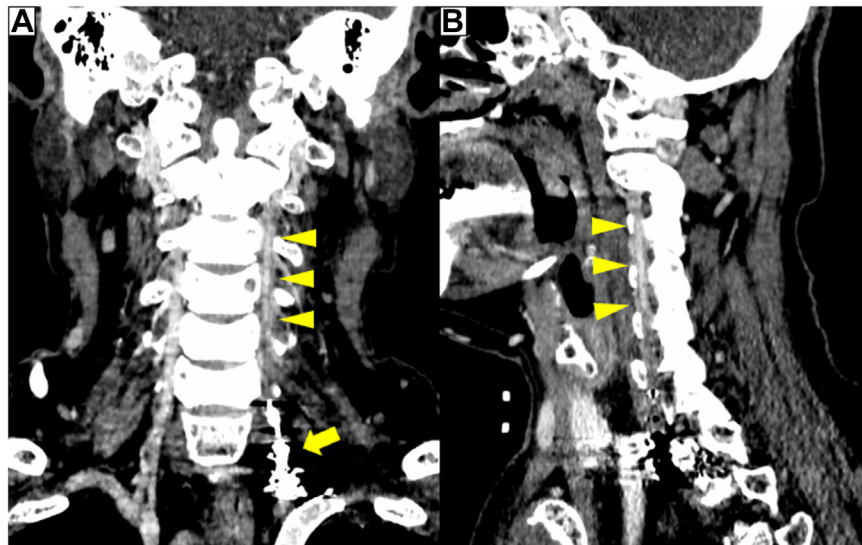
Contrast-enhanced computed tomography (CT) scan performed 2 months after endovascular treatment showing occlusion coils in the vertebral artery (VA; *yellow arrow*) and continued blood flow distal to the coils (*yellow arrowheads*). A, Arterial coronal view. B, Arterial sagittal view.
